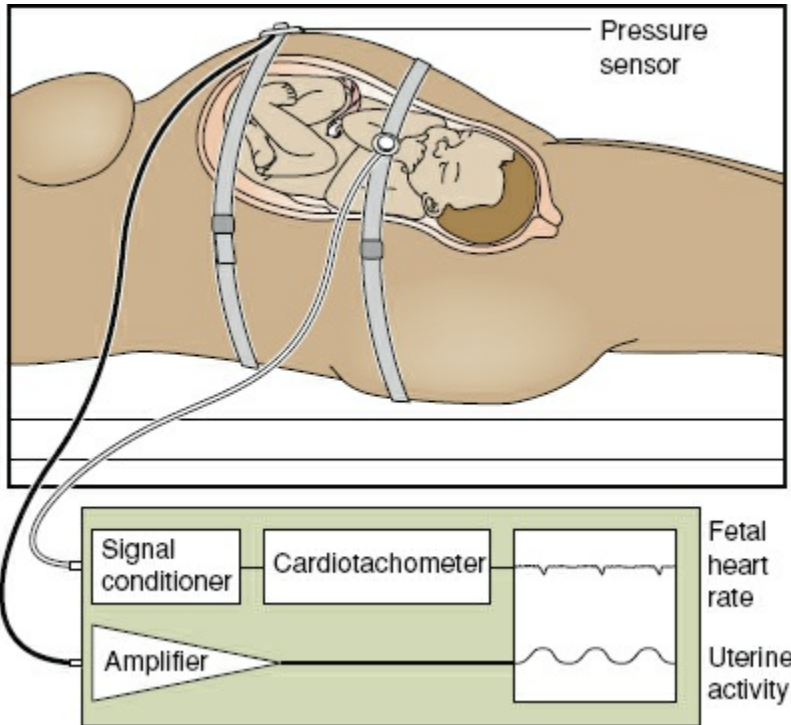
Intraoperative and postoperative fetal monitoring using noninvasive surface Doppler and pressure sensor to monitor uterine contractions. (Reproduced from Miller DA, Paul R. Antepartum–intrapartum monitoring. In: Scott JR, DiSaia PJ, Hammond CB, et al., eds. *Danforth’s Obstetrics and Gynecology*. 8th ed. Philadelphia, PA: Lippincott Williams & Wilkins; 1999:243–255.)
